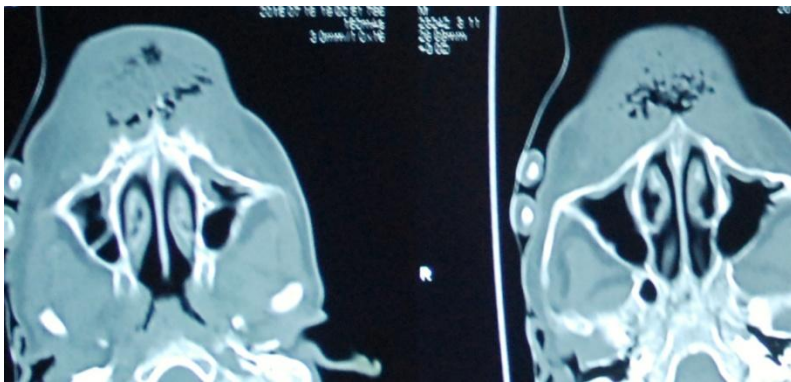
CT scan showing maxillary destruction due to Myiasis
